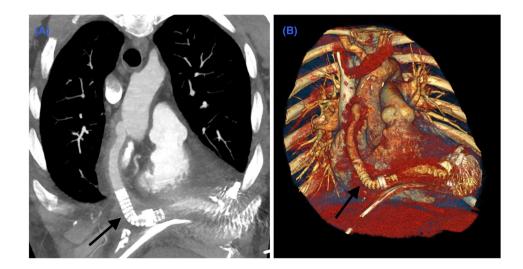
(A) Control coronal computed tomography angiography image with outflow graft showing a sufficient lumen and stent in situ (black arrow). (B) Three-dimensional computed tomography angiography reconstruction showing the stent in situ (black arrow).
